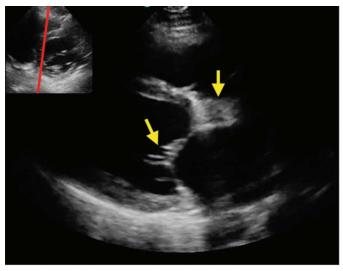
Tilting to find a central plane on parasternal long axis. On the left, the plane (red line) is medial to the center of the LV. As a result, chordal tissue and septal parts of the aortic outflow tract (arrows) are imaged. The image on the right shows a central plane (green line), which shows both the mitral leaflets and aortic cusps in view.
